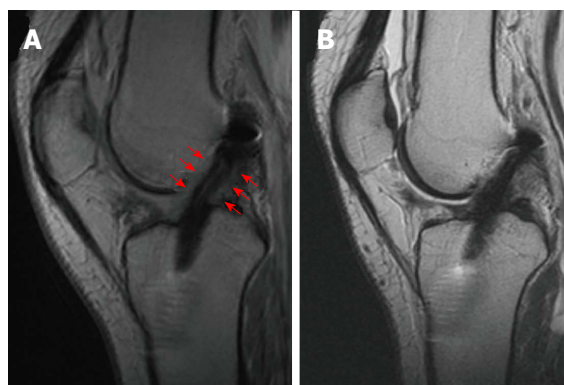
Successful anterior cruciate ligament reconstruction with Gracilis and Semitendinosus autograft with a normal healing process. At the 6th month, it is possible to appreciate in the T2-Fast recovery sat-spin echo (FRFSE) MRI a hyperintense line within the graft body. The graft is surrounded by an intermediate signal intensity tissue (red arrows), representing vascularization and synovialization (A). At the 12th month, the periligamentous signal has disappeared and the graft signal decreased resembling that of PCL (B). PCL: Posterior cruciate ligament; ACL: Anterior cruciate ligament; MRI: Magnetic resonance imaging.
